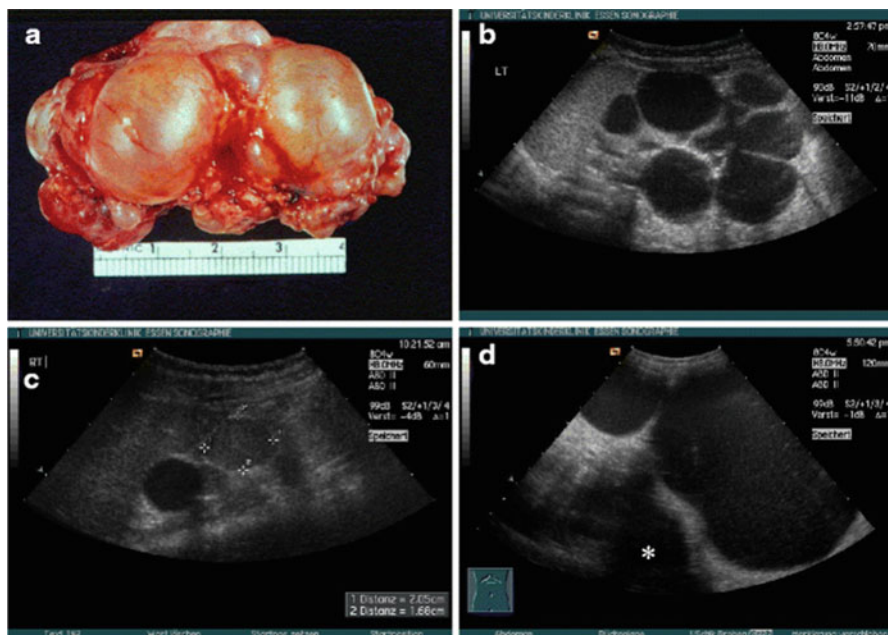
Polycystic kidneys. Panel a is the gross appearance, panel b is a sonographic depiction, panel c contrasts cyst appearance with a tumor (marked with calipers) and panel d represents very large cysts in a polycystic kidney
